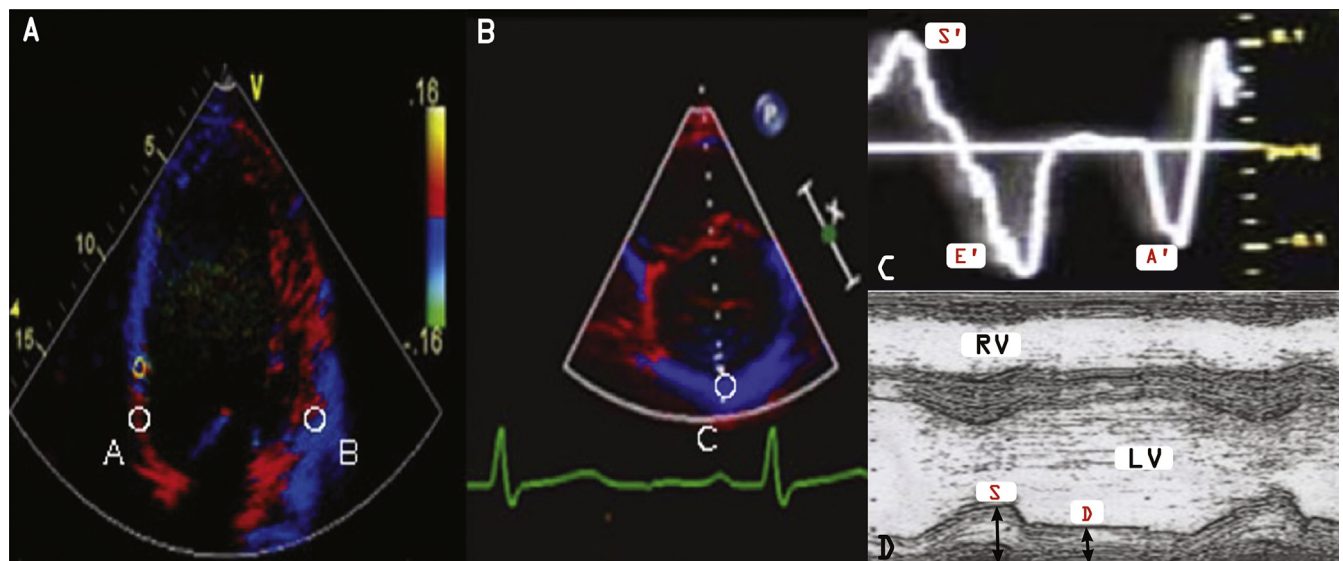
(A, B) Areas of the left ventricle where the spectral Doppler tissue image was obtained (points A, B and C) for the calculation of the LVRI. A = interventricular septum, B = lateral wall of the left ventricle, C = posterior wall of the left ventricle. (C) Tissue Doppler trace of the velocities derived from the color images. E' was the only tissue velocity utilized for the calculation. (D) M-mode trace demonstrates the measurement of the LVPW in systole (S) and diastole (D) for the calculation of LVPW thinning used in the denominator of the LVRI. RV, right ventricle; LV, left ventricle.
